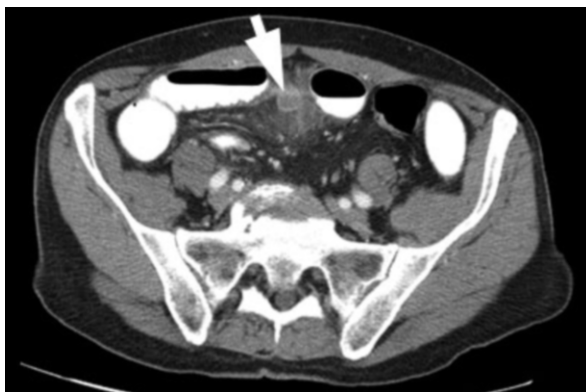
CT axial images with oral and intravenous contrast. A fluid filled diverticulum associated with the neighboring bowel can be seen at the midline (arrow).
